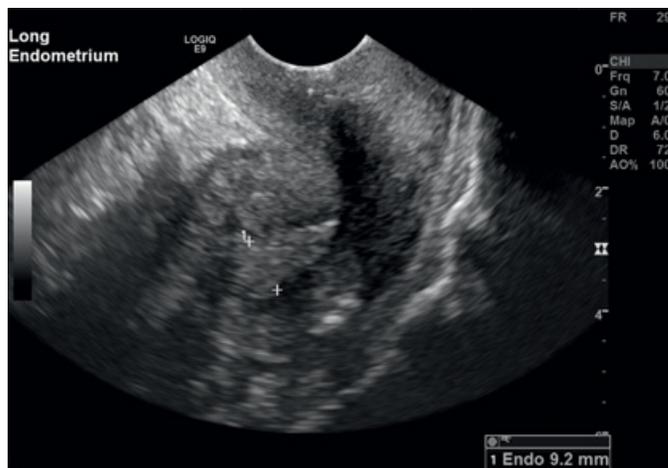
Transvaginal ultrasound image of a postmenopausal patient with a thickened endometrium.
